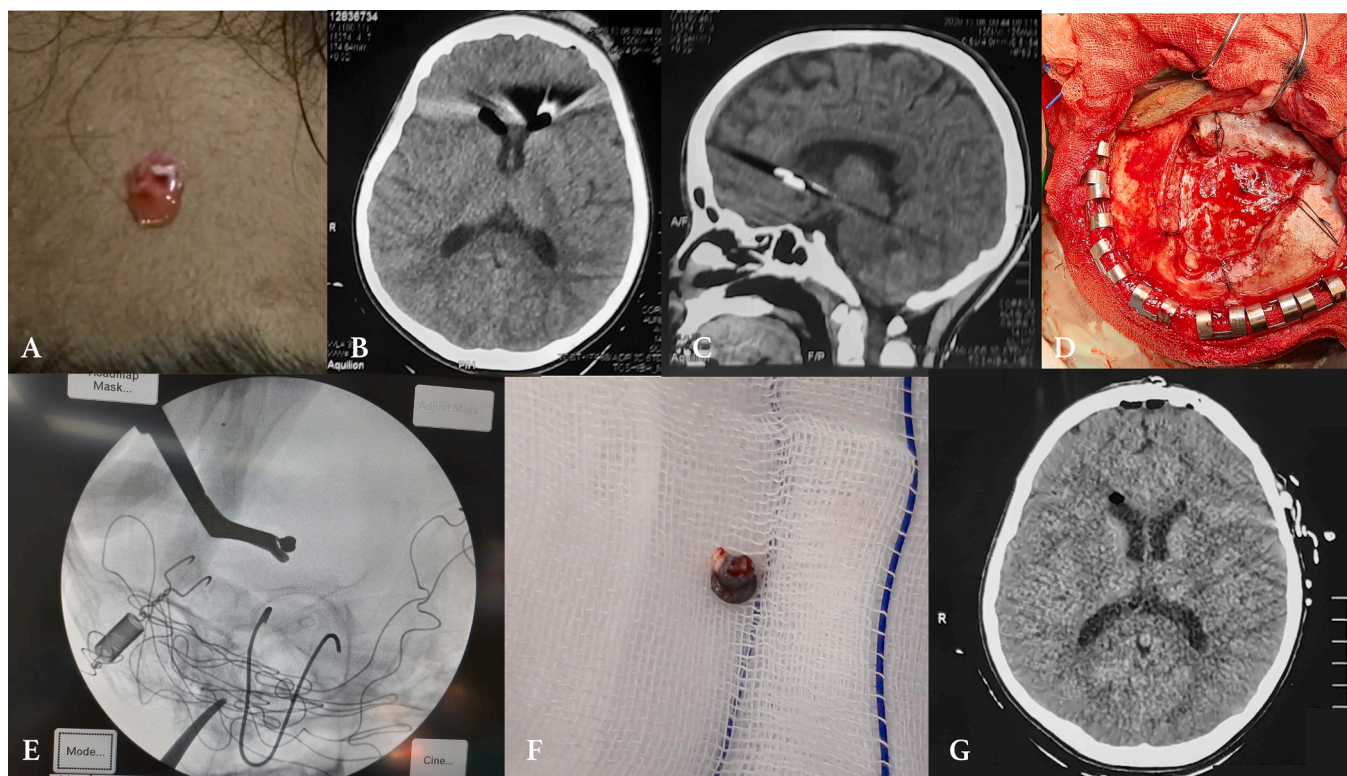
Round-shaped open wound on the left frontal region showing bone discontinuity and pulsatile egression of clear fluid, following the heartbeat (a). Head CT showed a hyperdense lesion with the same density of bone tissue in the left lateral ventricle indicating a foreign body and its trajectory along the frontal lobe. Pneumocephalus in the left frontal lobe and bilateral lateral ventricles. Trajectory of bullet showing the bullet lodged just by the head of caudate nucleus (b-c). Intraoperative craniotomy and dural exposure (d). C-arm guided foreign body extraction. Extraction was done through bullet's trajectory into the site (e). Foreign body extracted (f). Post-operative evaluation with head CT scan of axial view view showed complete removal of bullet with no postoperative hemorrhages (g).
